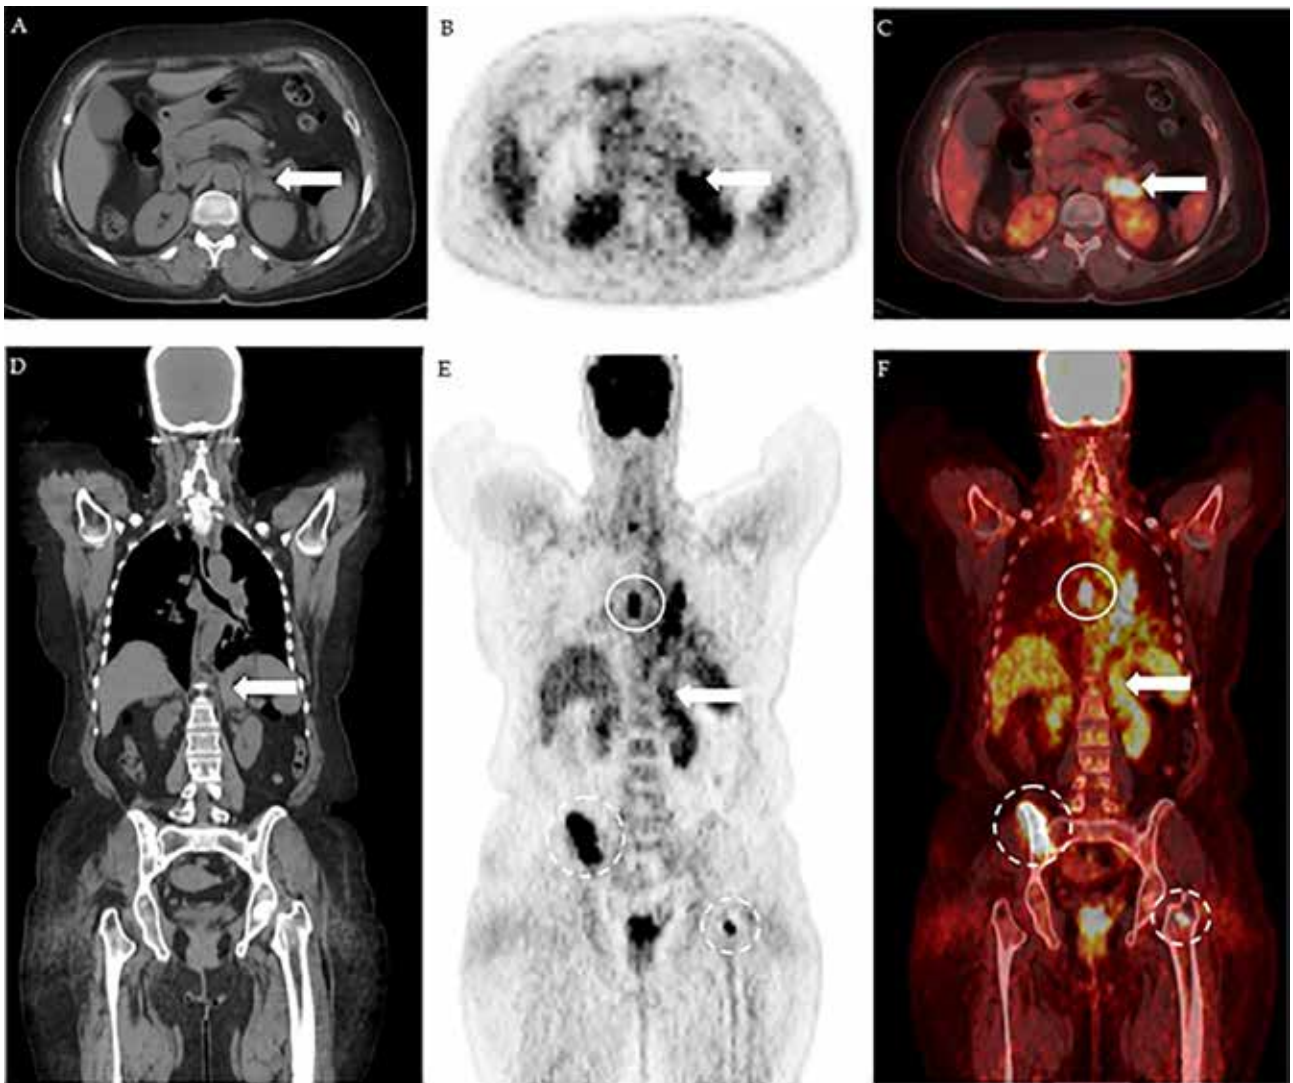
Adrenal metastasis is depicted on axial unenhanced CT (A), attenuation-corrected ^{18}F -FDG PET (B) and fused PET/CT images (C). CT displays a well-circumscribed left adrenal tumor (arrow); increased ^{18}F -FDG uptake is observed on PET and PET/CT. The primary lung cancer (continuous circle) and metastatic bone lesions (dashed circle) are seen on coronal plane of these images (D-F). (Refaat R, Elghazaly H. Employing ^{18}F -FDG PET/CT for distinguishing benign from metastatic adrenal masses. *Egypt J Radiol Nucl Med* 2017; 48: 1065-1071)
